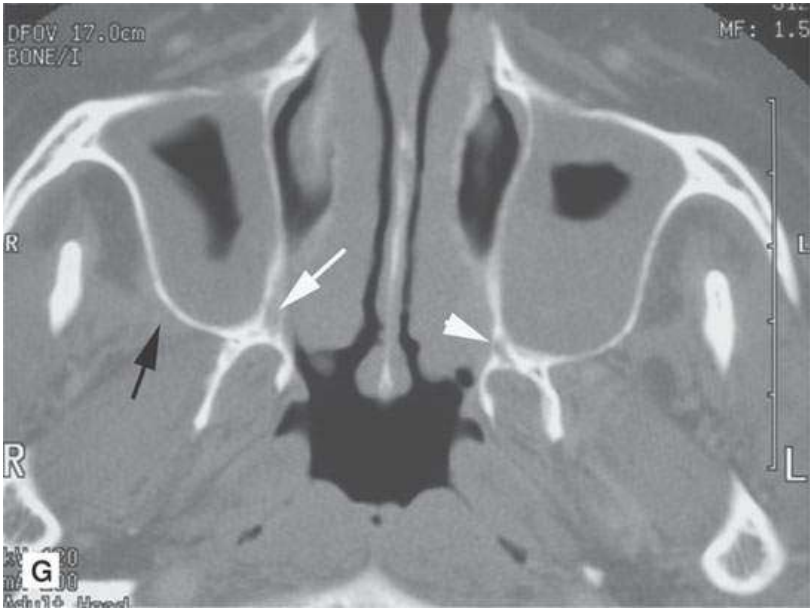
Contrast-enhanced computed tomography study of a patient with neurotropic lymphoma conforming to the nerve anatomy manifest by enlargement and minimal enhancement along the course of the affected nerves and obliteration of tissue planes around those nerves with remodeling of adjacent bones. A: Spread along the cranial nerves of the cavernous sinus into the orbit via the superior orbital fissure (*white arrow*). Thickening along the zygomatic division branches of the facial nerve (*arrowheads*). B: Spread along the cranial nerves of the cavernous sinus (*black arrows*). Thickening along the zygomatic division branches of the facial nerve (*white arrows* and *arrowheads*). C: Spread along the posterior superior alveolar branches of V2 (*arrows*) with enlargement of the pterygopalatine fossa (*arrows*). D: Spread along the posterior superior alveolar branches of V2 (*arrows*) and enlargement of the greater palatine foramen due to involvement of that branch of V2 (*arrowheads*). Thickening of the zygomatic division of the facial nerve (*black arrow*). E: Bone windows showing enlargement of the pterygopalatine fossa (*arrow*) and vidian canal (*arrowhead*). F: Bone windows showing enlargement of the pterygopalatine fossa (*arrow*) compared to the normal side (*arrow*). G: Bone windows showing enlargement of the greater palatine foramen (*white arrow*) compared to the normal side (*arrowhead*) and no bone erosion where the posterior superior alveolar nerve is involved (*black arrow*).
